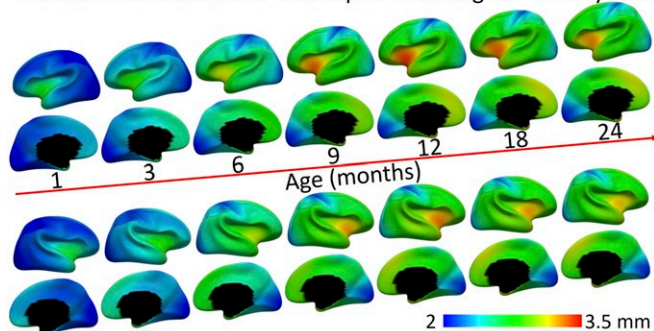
Vertex-wise maps of CT development at different ages.
